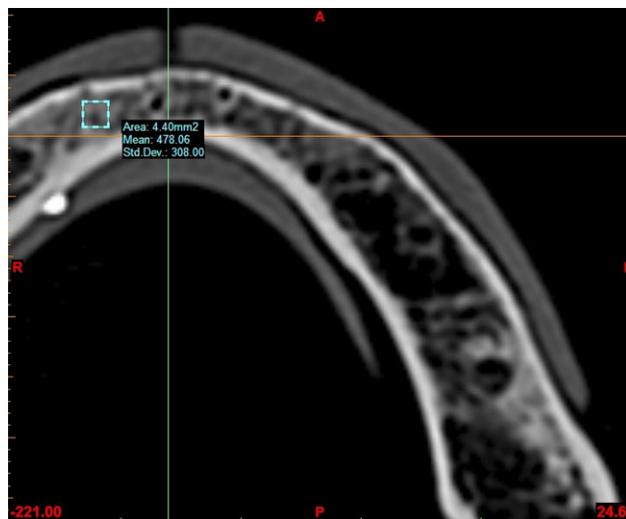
Determination of cancellous bone computed tomography gray density values (Hounsfield unit [HU]). It should be noted that the area and the coordinates of the drawn square are the same as in Figure 5 (-221.00, 24.60). The mean gray density value recorded was 478.06 HU.
